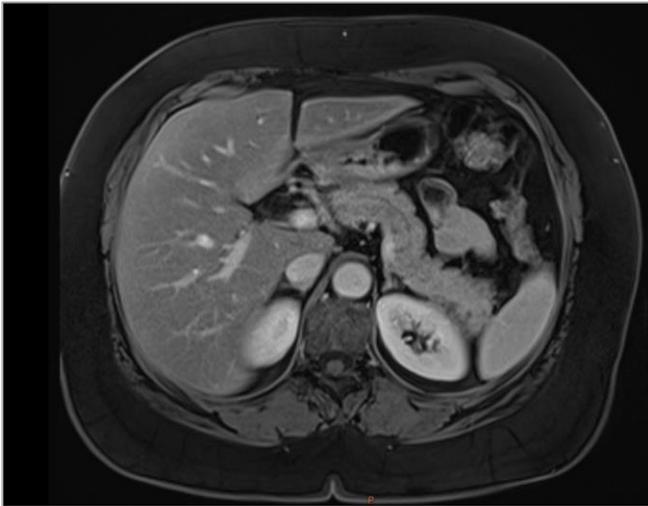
MRI axial T1-weighted image with contrast administration demonstrating normal-appearing adrenal glands.
